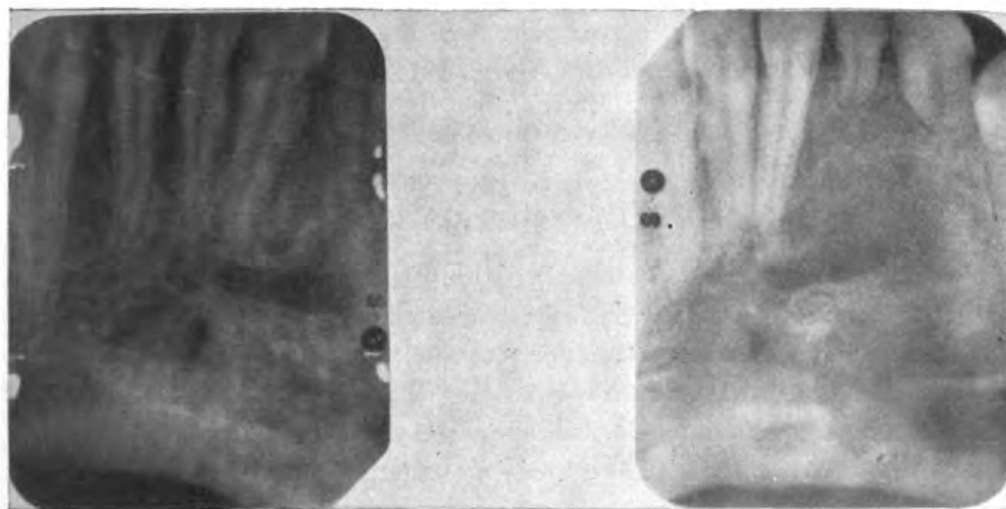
Postoperative dental radiographs.
